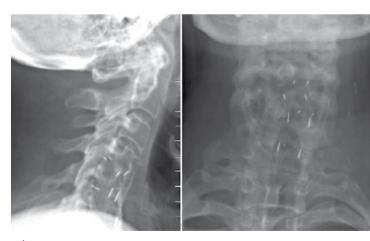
X-rays after the injury.
